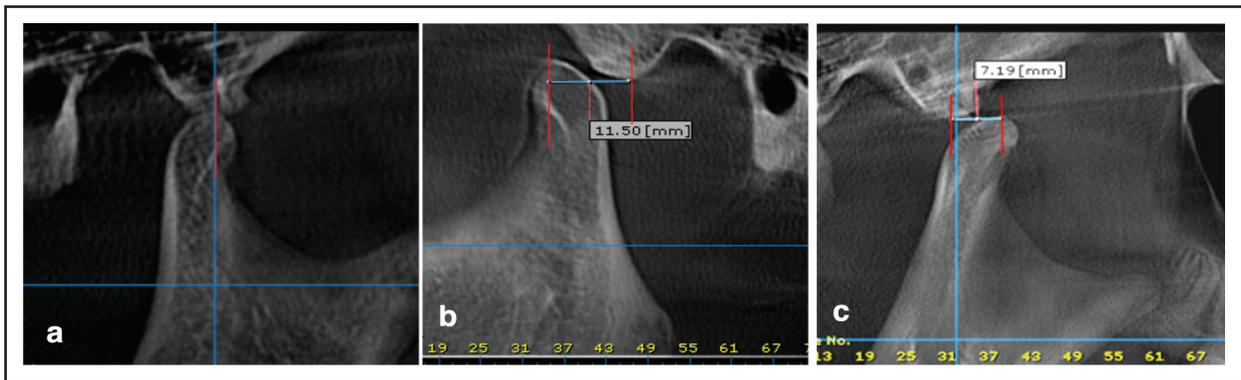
Sagittal CBCT cuts showing the measurement of DCLL for different patients. The red lines representing the lines passing through the highest point of the condyle and the lowest point of the eminence. The blue line means the distance between them referring to (DCLL). a) 0 mm measurement of DCLL (subluxation), b) High degree of DCLL in negative value measuring (-11.50 mm) which indicates that the condyle moved large distance in front of the eminence, and c) Moderate amount of DCLL in negative value (-7.19 mm).
